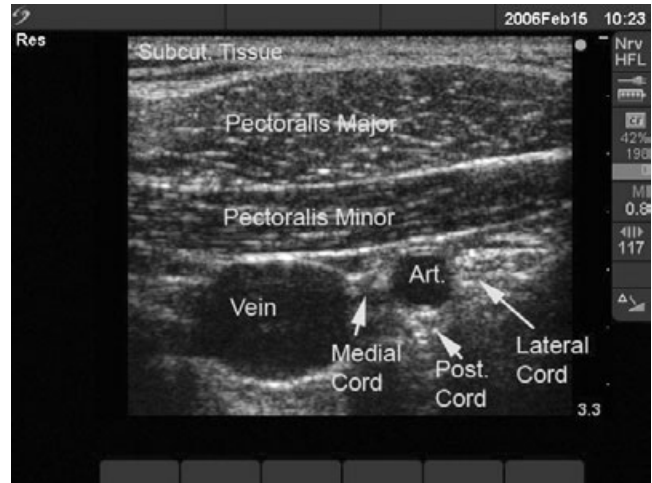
Ultrasound image of the brachial plexus in the infraclavicular area. Note how the cords surround the artery with the medial cord located between the vein and the artery. Art., artery; Post., posterior; Subcut., subcutaneous.
